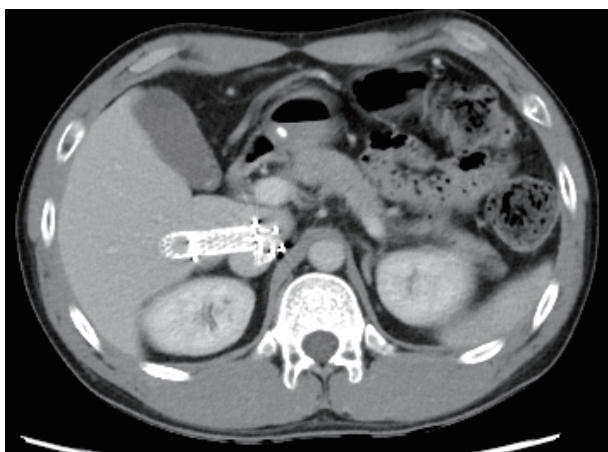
Follow-up abdominal CT after 6 years of treatment confirmed stent patency and no ascites.
